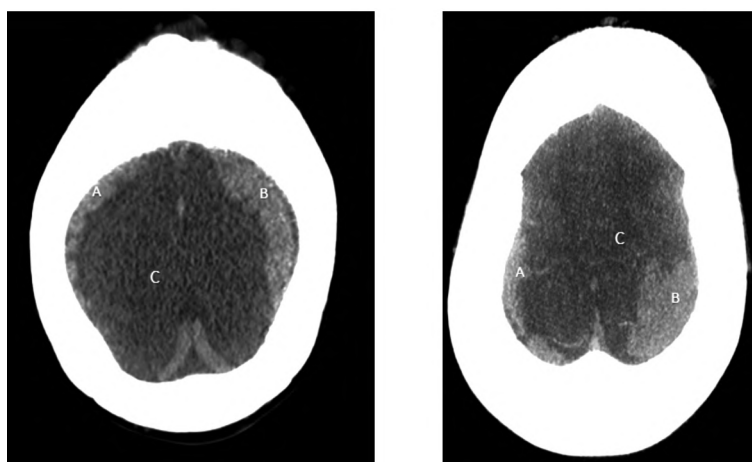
Skull CT scan showing hyperdense tissue along the parietal convexities and around the superior sagittal sinus (A, B) that are related to areas of extra-medullary hematopoiesis. Note the edematous low density brain parenchyma (C).
